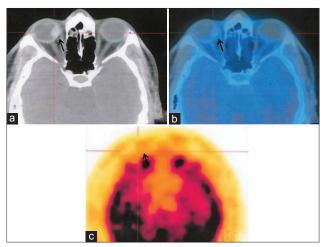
(a) Transaxial computed tomography scan image of case 3 showing the intraocular mass in right eye (black arrow). (b) Fused transaxial image and (c) positron emission tomography transaxial images showing poor fluorodeoxyglucose uptake with maximum standardized uptake value 1.3
